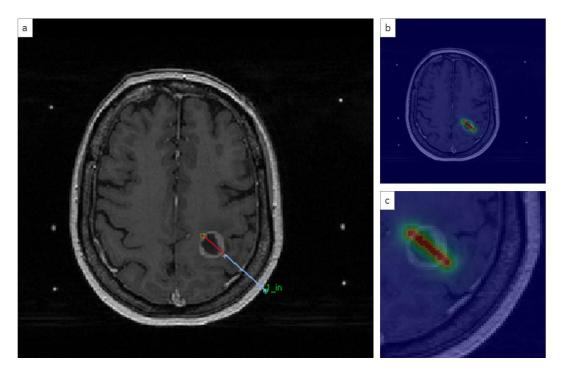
Light distribution computed from one single 20 mm cylindrical diffusor in a TPS dedicated to iPDT <sup>62</sup>. a) Interstitial fiber, where the red line represents the diffusing part and the blue line represents the non-diffusing part. b) Superposition of the MRI and the fluence rate matrix with a colored look-up table. c) Zoomed in an area where the fiber is inserted. Discretization of the representation matches with the MRI resolution. Here, the fluence rate matrix was computed using the analytical discrete model.
